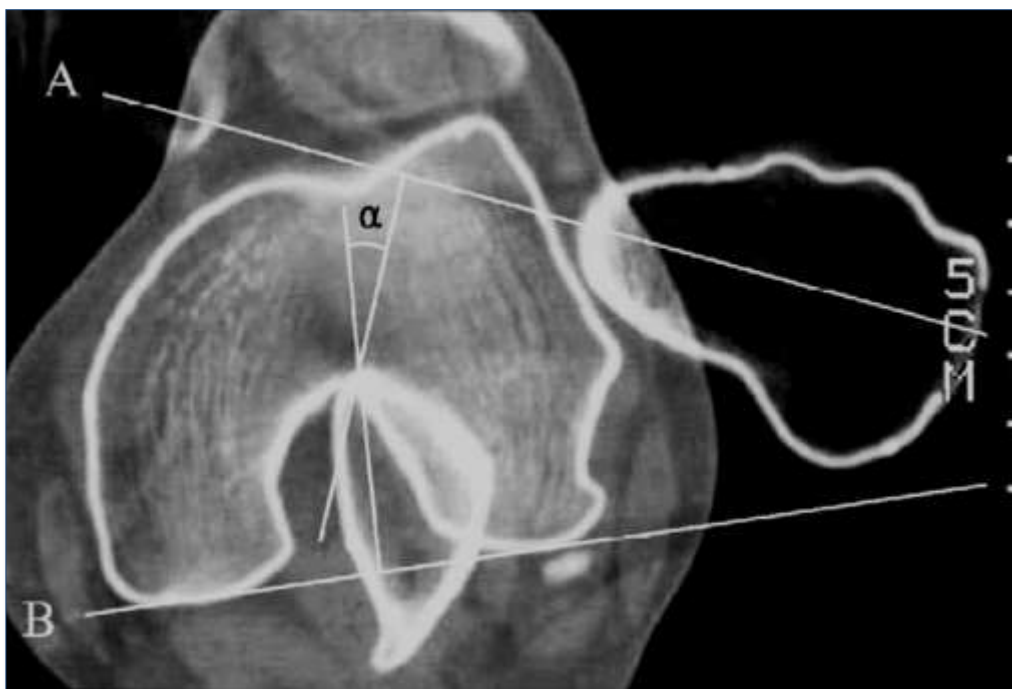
FNA Measurement using superimposed axial CT scans, reproduced from (Suh et al., 2006); A = femoral neck axis; B = transcondylar axis of the femur.
